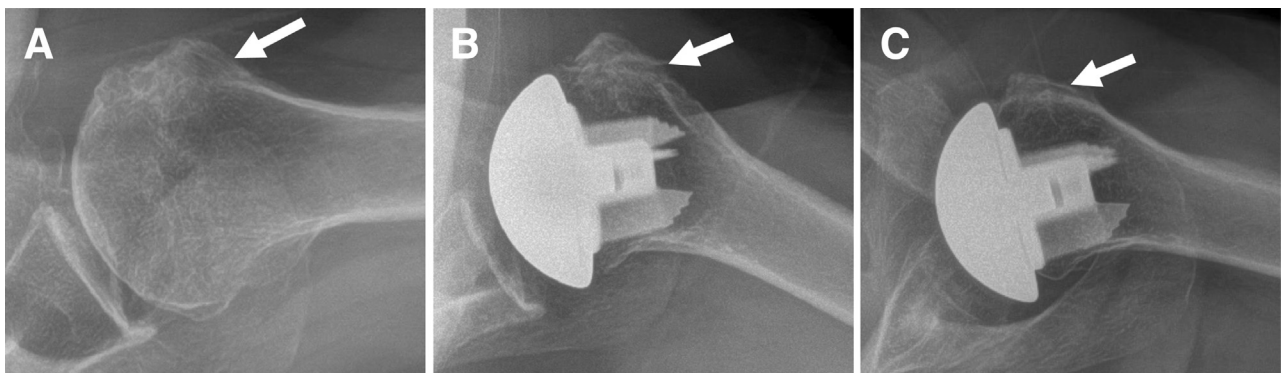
Representative radiographic surveillance of a lesser tuberosity osteotomy repair for a left shoulder in anatomic shoulder arthroplasty. (A) Axillary-lateral view preoperatively of a left shoulder with glenohumeral arthritis before undergoing an anatomic replacement. (B) Axillary-lateral view 2 weeks postoperatively after lesser tuberosity osteotomy. (C) Axillary-lateral view 10 months postoperatively after lesser tuberosity osteotomy showing well-healed osteotomy site.
